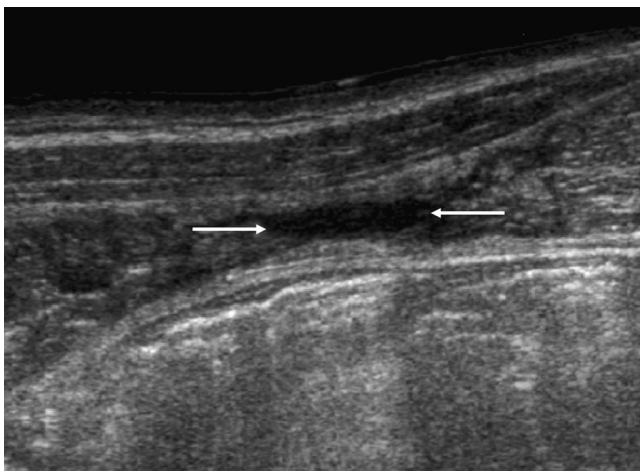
Abdominal wall muscle tear. The patient had an acute history of trauma to the right lateral abdominal wall. An oblique sonography, showing discontinuity of the internal and external oblique abdominal wall muscle fibers with hematoma filling up the gap (arrows). The features are compatible with muscle tear.
